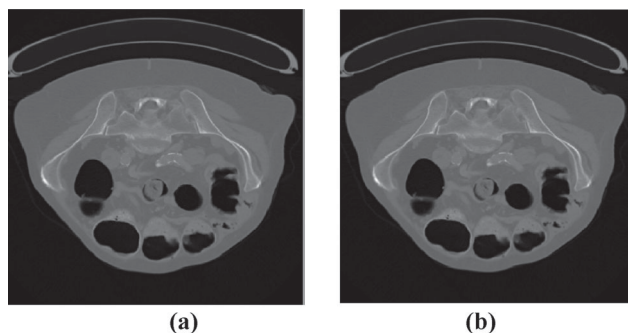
CT-6 Spiral Arterial scan image from data set-3 of Table 1 (a) Original Image (b) Image reconstructed with VLIC method [35].
